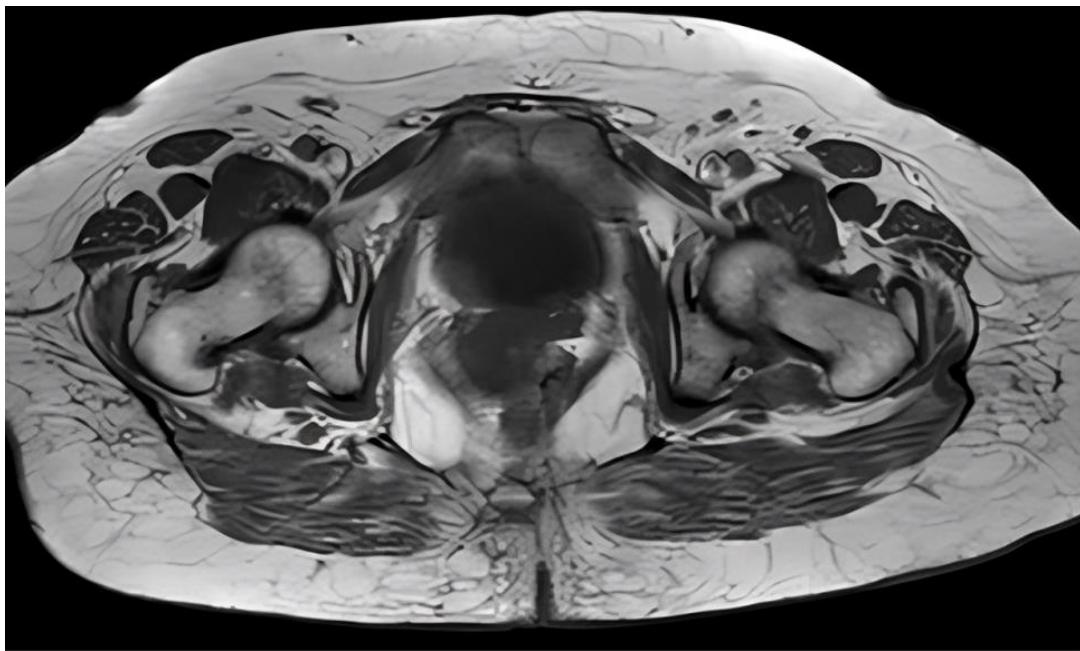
Axial T2-weighted MRI sequence showing a well-defined uterine mass with regular contours and homogeneous low T2 signal intensity (Case 1).
